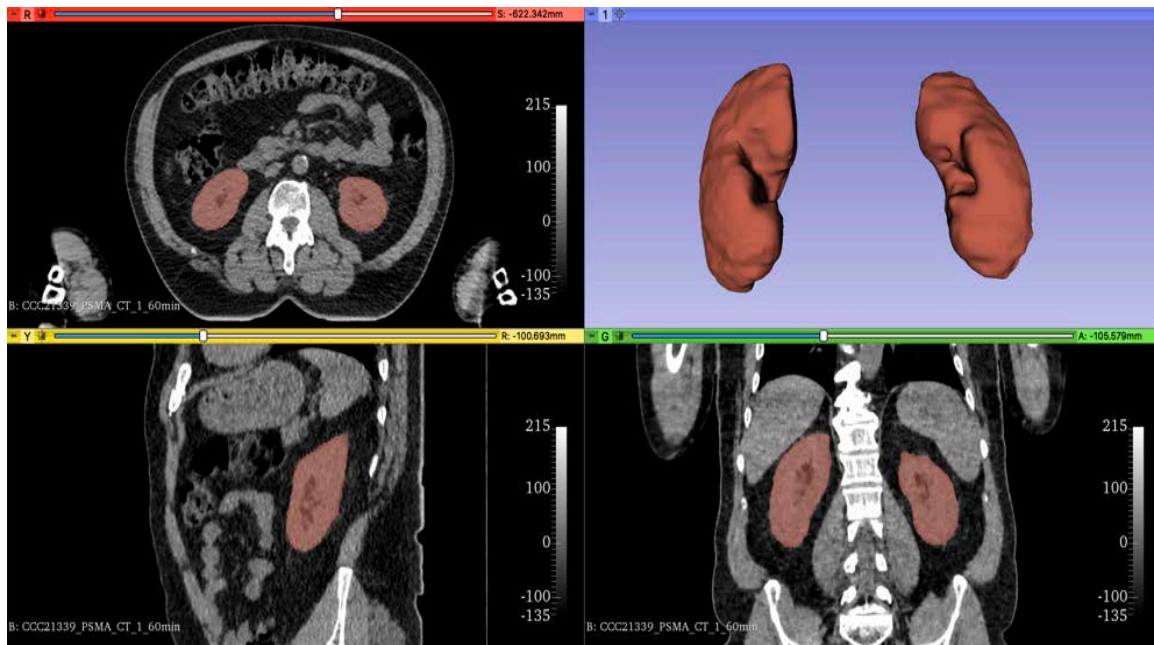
Mask created from manual segmentation of the kidneys in the axial (R), coronal (G), and sagittal (Y) slices of a patient CT image. A 3D view (1) of the obtained segmentation is also represented. The 'Grey' colormap was selected in Slicer. The color scale was adjusted to vary between black (low-density tissues) at -135 and white (high-density tissues) at 215.
